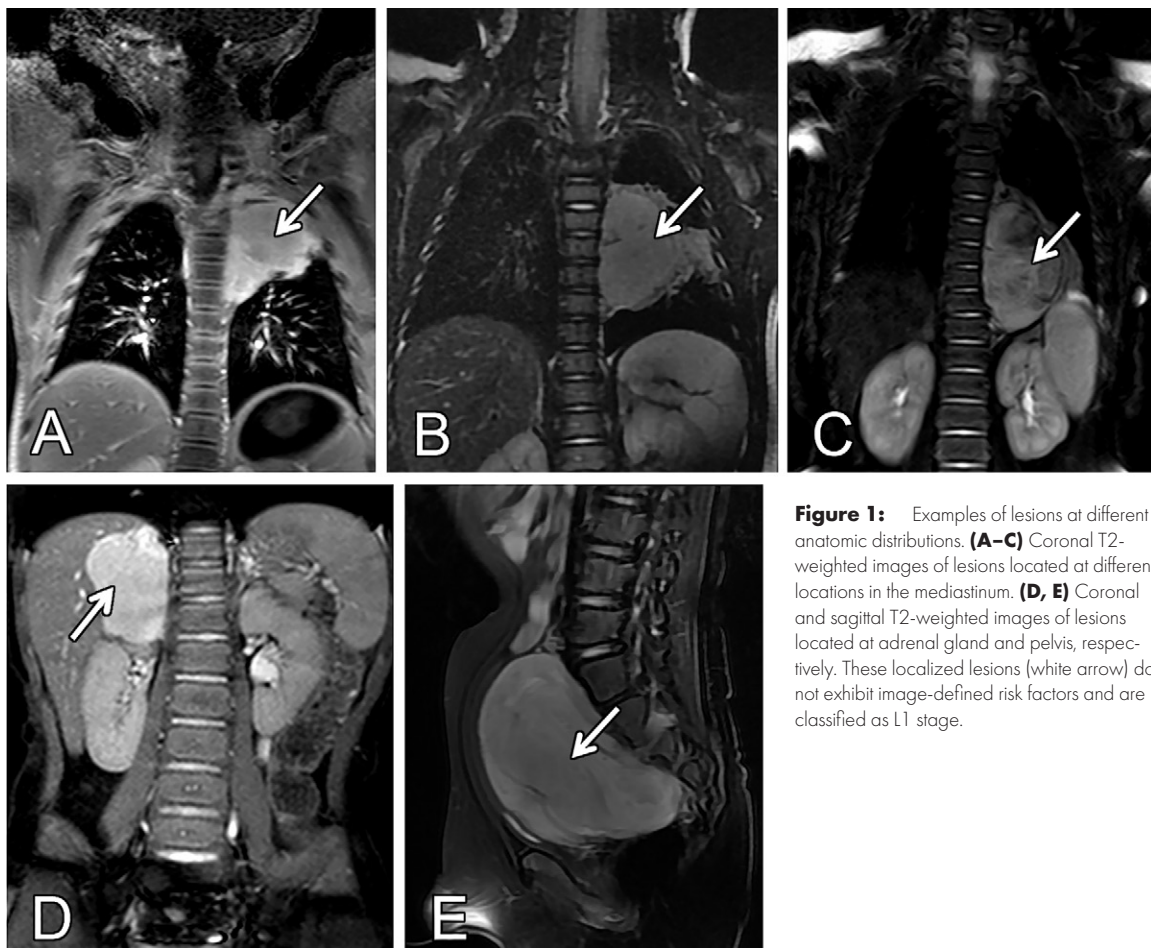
Examples of lesions at different anatomic distributions. (A–C) Coronal T2-weighted images of lesions located at different locations in the mediastinum. (D, E) Coronal and sagittal T2-weighted images of lesions located at adrenal gland and pelvis, respectively. These localized lesions (white arrow) do not exhibit image-defined risk factors and are classified as L1 stage.
